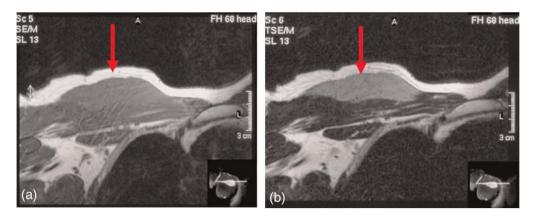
Initial MRI demonstrated a chest wall mass lesion with an intermediate signal on T1-weighted imaging (a) and an intermediate signal on T2-weighted imaging (b). The boundary between the mass lesion and muscle seemed clear
